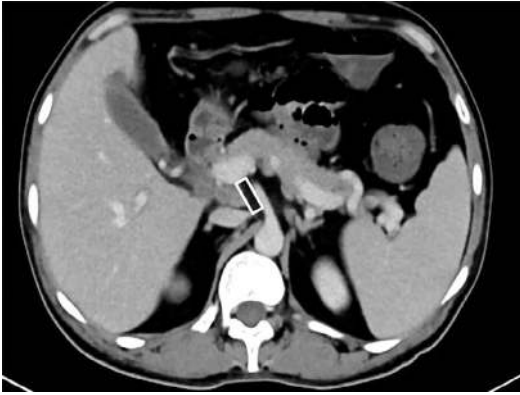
Axial contrast CT image showing retroportal lamina (box)
